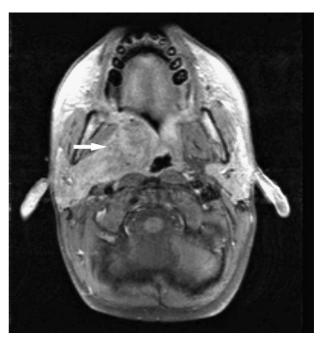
Spin echo T1-weighted magnetic resonance (MR) image after intravenous (i.v.) contrast enhancement. The arrow indicates the residual tumour mass in the right pterygoid fossa.
